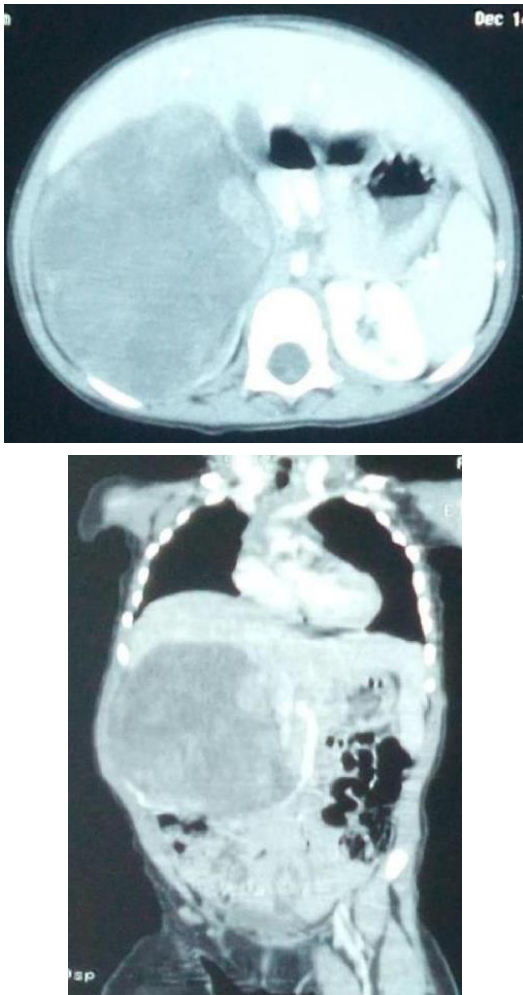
Computed tomography appearance of a bulky abdominal mass, unencapsulated, heterogeneous density and whose relationships with the kidney are imprecise
